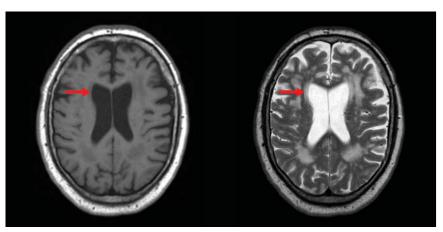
MRI OF A BRAIN with T1 (left) and T2 (right) weighting. T1 refers to the time required for precessing nuclei in tissue to relax to their equilibrium orientation in a magnetic field, and T2 refers to the time it takes the nuclei to lose their phase coherence. The timing of RF pulses can be chosen so that the MRI signal comes from tissue with the shortest T1 times or the longest T2 times. Images taken with those different timings demonstrate how MRI can be tuned to produce different signal intensities in the same tissue. Fluid-filled ventricles (red arrow) are darker than the brain tissue on the T1-weighted image and brighter on the T2-weighted image. (Images by David Jordan, University Hospitals Cleveland Medical Center.)
